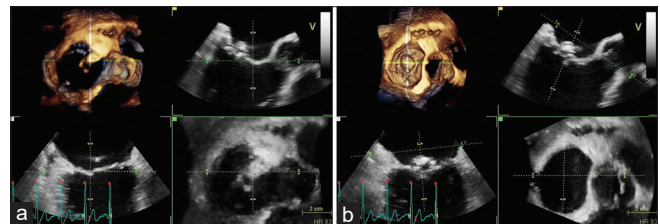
Postprocessing of three-dimensional echocardiographic dataset. (a) Auto dissection of three-dimensional data set into 3 orthogonal planes. The yellow, white and green dotted lines show the plane orientation and yellow, white and green corner square markings show the two-dimensional image in the corresponding plane; (b) For viewing the mitral valve *en face*, the green plane is chosen as the viewing plane and the yellow and white planes are the orthogonal planes. The orthogonal planes are steered to dissect the mitral valve longitudinally through the center of the mitral orifice. The viewing plane (green) is then steered to be perpendicular to the crosshair formed by the orthogonal planes (yellow and white) so that it is perfectly parallel to the mitral valve. By using "flip crop" and axial "z" rotation of the viewing plane, the prescribed surgeon's view can be shown
